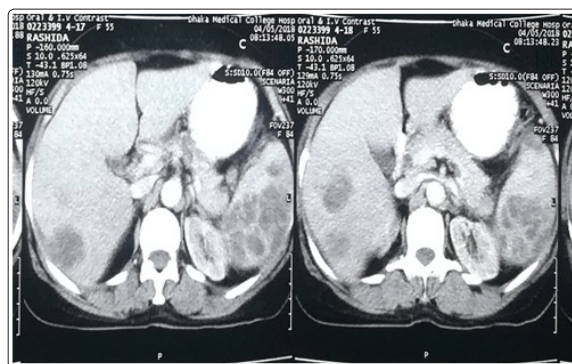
Contrast-enhanced CT of the abdomen of the patient demonstrating multiple, relatively well-defined, hypoenhancing lesions of varying sizes involving the liver and spleen
